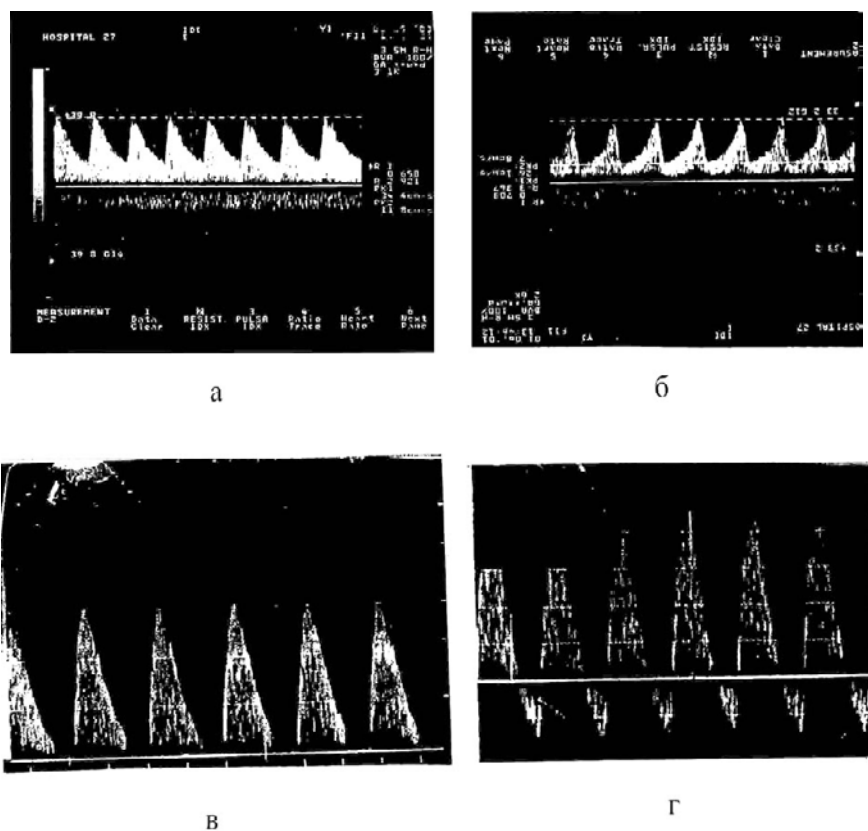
Dopplerometric indices of pregnant Ekaterinburg residents: a – healthy fetus; б – initial stage of placental insufficiency; в – absence of diastolic component in all heart cycles; г – reverse diastolic component of the blood flow in all heart cycles.
